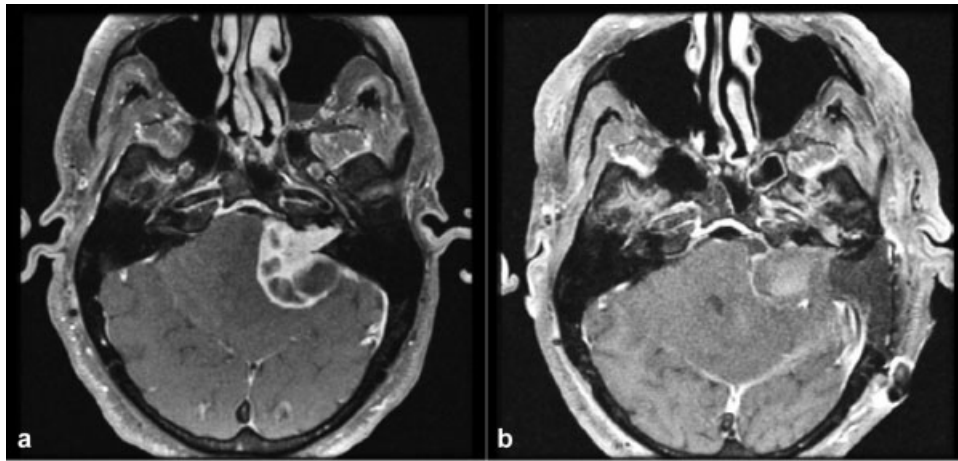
Post-gadolinium T1-weighted axial MRI (a, preoperative; b, postoperative) showing successful decompression of the brainstem.
